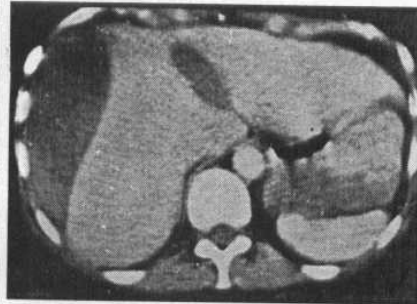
Plain CT Scan showed a big subcapsular hematoma.
